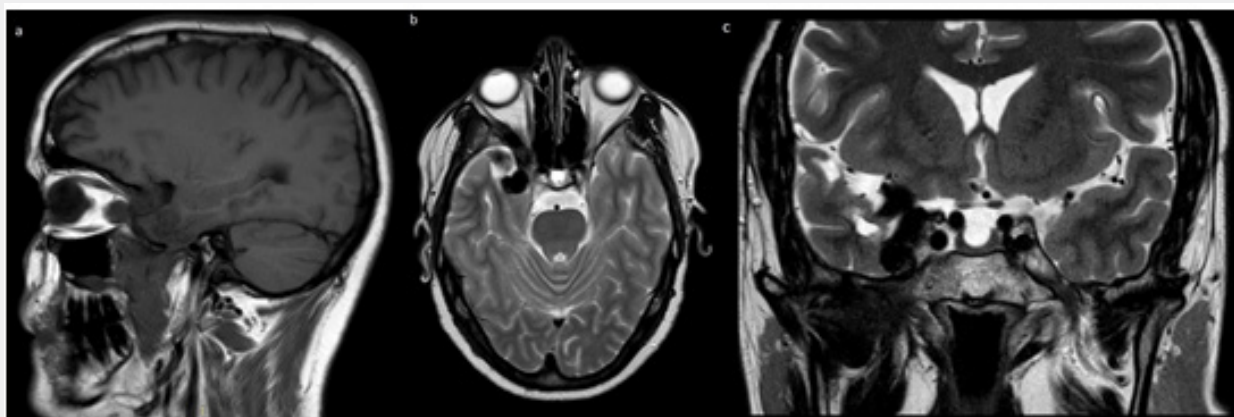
Postoperative MRI (a) T1 weighted image in sagittal section, (b,c) T2 weighted image in axial and coronal section.
